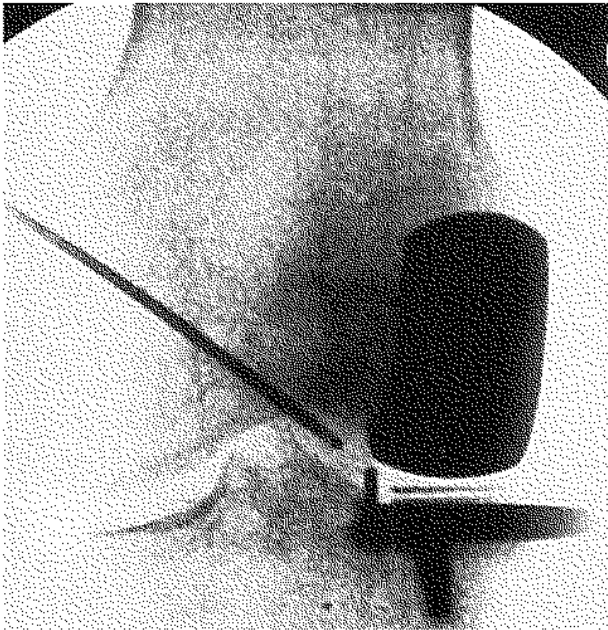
AP radiograph showing a reduced lateral meniscal bearing, after a successful arthroscopic manipulation with the hook palpator.
